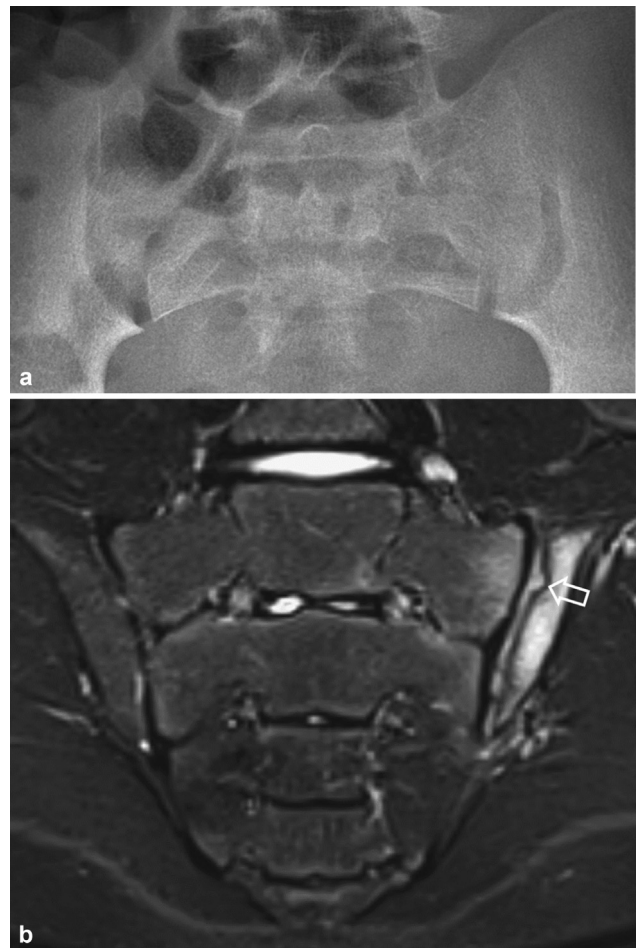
A 14-year-old boy with active sacroiliitis associated with inflammatory bowel disease (colitis ulcerosa). (a) Radiograph shows a normal image; no lesions are seen. (b) Supplementary magnetic resonance semi-coronal short tau inversion recovery (STIR) image can depict early active lesions such as bone marrow edema, as seen here on both the iliac and sacral side of the left sacroiliac joint (SIJ). Also note the joint inflammation and the active erosions at the iliac side of the left SIJ (arrow).
